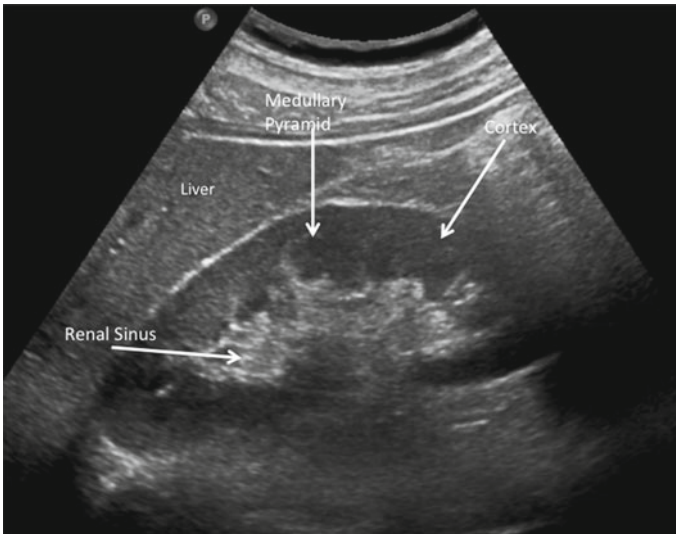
Normal sonographic appearances of the right kidney with major structure labelled
